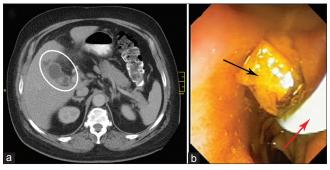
(a) Computed tomography scan image shows the localized perforation in the gallbladder (circled white). (b) Endoscopic image of stentolith with stent *in situ* (stent with red arrow and stentolith with a black arrow)
